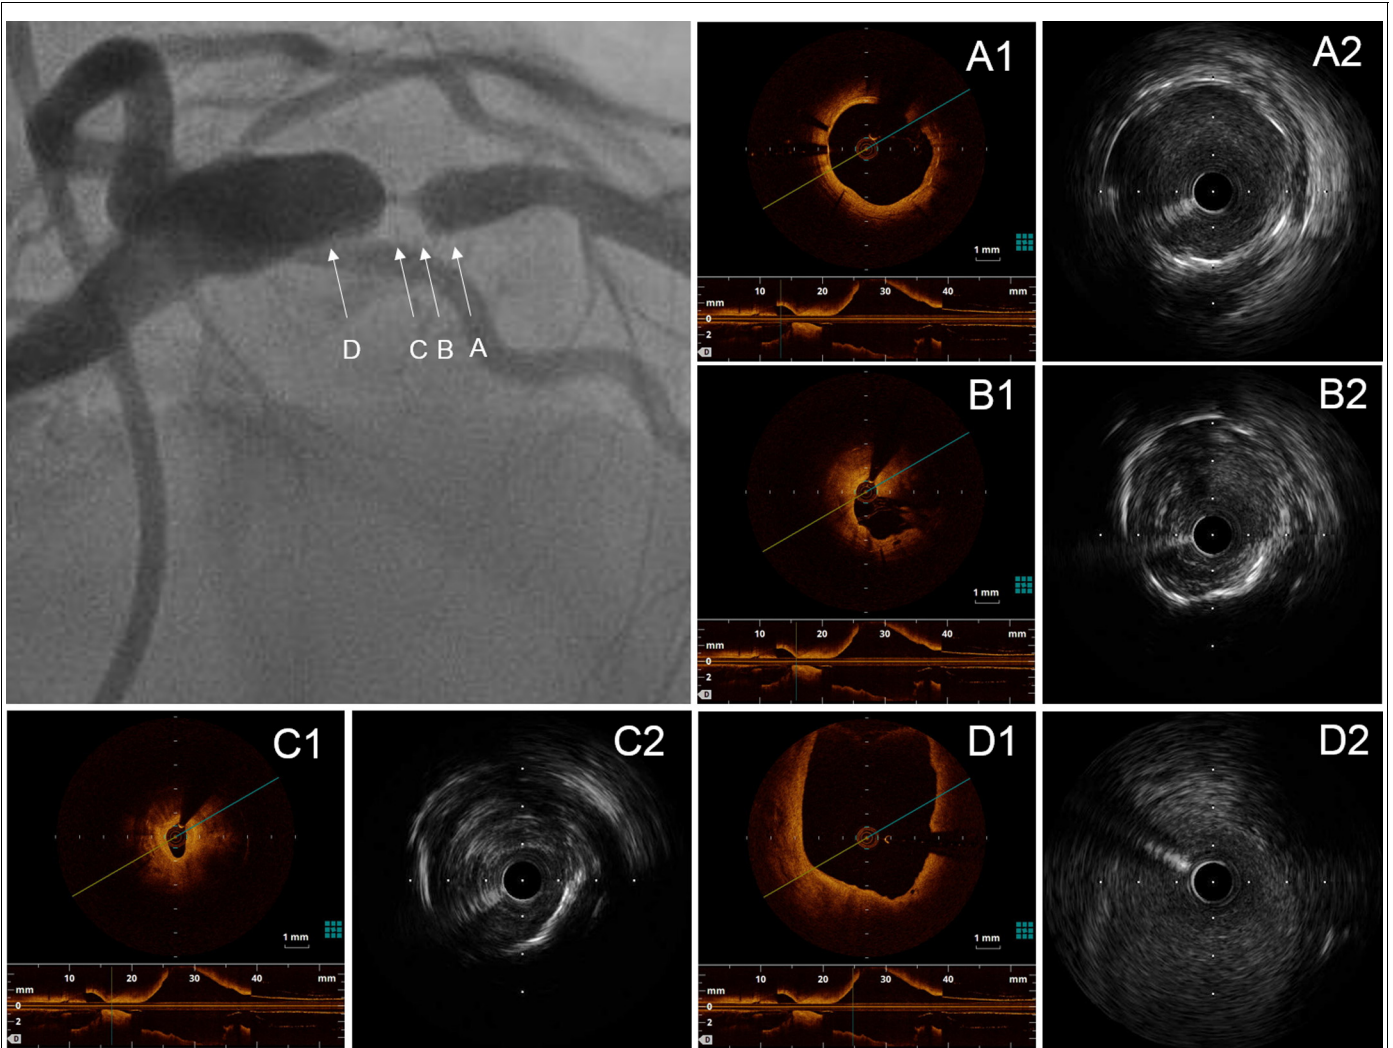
Right anterior coronary view on left coronary angiography (arrows, A–D), optical coherence tomography images (panels A1, B1, C1, and D1), and intravascular ultrasound image (panels A2, B2, C2, and D2) before catheter intervention. Panel A1 and A2, the well-dilated bare metal stent was covered by neointima. Panel B1 and B2, the culprit lesion with inaintima neovascularization. Panels C1 and C2, the severe restenosis site with an attenuated signal intensity. Panel D1 and D2, the inlet of the aneurysm with inaintima neovascularization.
